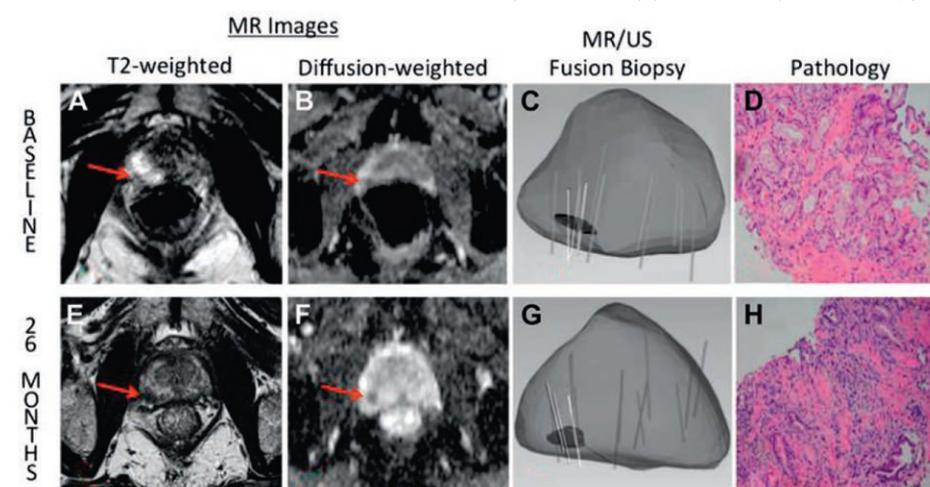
Example of serial MRI used to indicate progression of low risk lesion. Axial T2-weighted image (A) demonstrates hypointense lesion in right apical peripheral zone. Diffusion weighted image (B) indicates apparent diffusion coefficient of 1,128. Overall PI-RADS score is 3. MRI-US fusion biopsy (C) revealed Gleason 3+3 cancer in target (D). After 26 months index lesion appears larger (E) and apparent diffusion coefficient decreased to 916 (F). PI-RADS score is now 4. Repeat targeted biopsy (G) reveals Gleason 3+4 (H). Thus, serial MRI indicated more suspicious lesion than noted at baseline and repeat biopsy confirmed disease progression. Tracking biopsy of original cancerous site could have been performed without repeat MRI (fig. 1).
